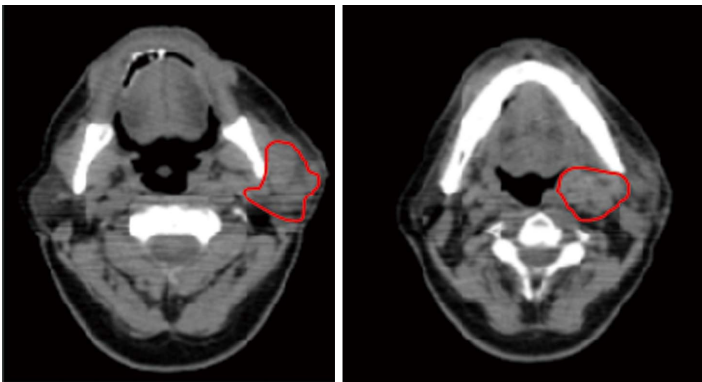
Computed tomography scan showed that the only site of persistent disease was the lymph node mass in the neck (December 2012).
